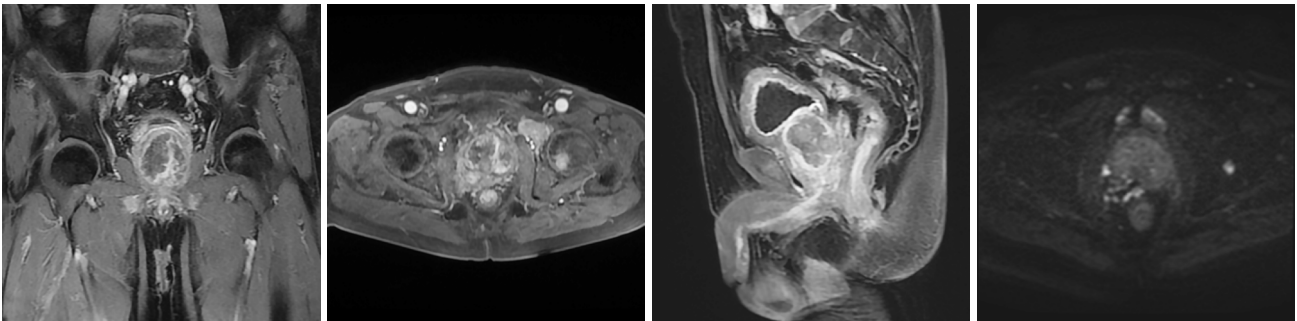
MRI findings at 1 month after the operation: the PV was approximately 4.3 cm × 3.0 cm × 4.0 cm at 1 month after the operation, the soft tissue mass shadow was smaller than that in previous MRI findings, and the range of the DWI sequence with high signal intensity continued to decrease. MRI, magnetic resonance imaging; DWI, diffusion-weighted imaging; PV, prostate volume.
